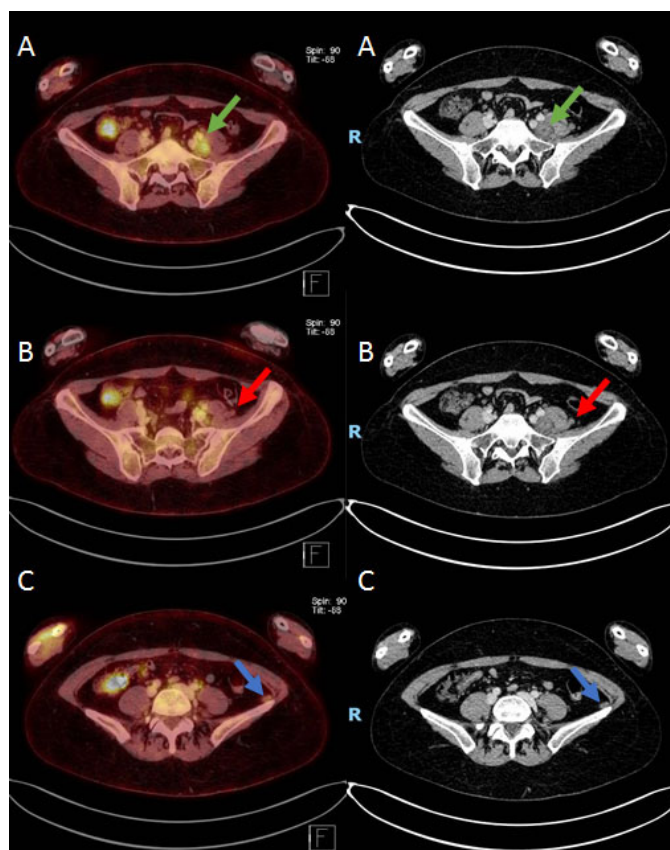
Left side – Fusion of metabolic images (PET), Right side – anatomical images (CT). (A) and (B) Two lesions with increased contrast enhancement, located medially (green arrows) and laterally to the left iliopsoas muscle (red arrows). (C) Small lesion in the intraperitoneal fat on the left flank, in the plane of the iliac crest (blue arrows).
